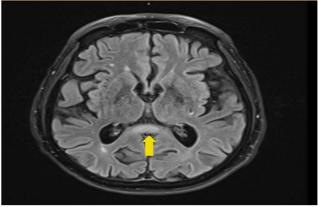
magnetic resonance imaging of the brain showing focal area of signal abnormality within the splenium of corpus callosum (yellow arrow).
